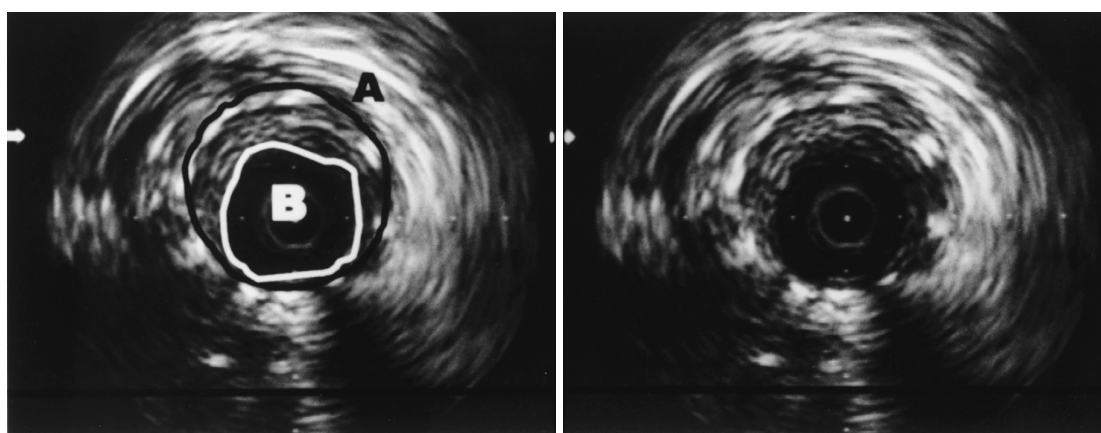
This figure shows the methods to calculate intimal hyperplasia (IH) cross-sectional area (CSA) and percent IH CSA. Left and right follow-up intravascular ultrasound images are identical. A and B represents stent CSA and lumen CSA at follow-up, respectively. IH CSA (mm²) : A - B, Percent IH CSA (%) : 100 × (A - B)/A.
